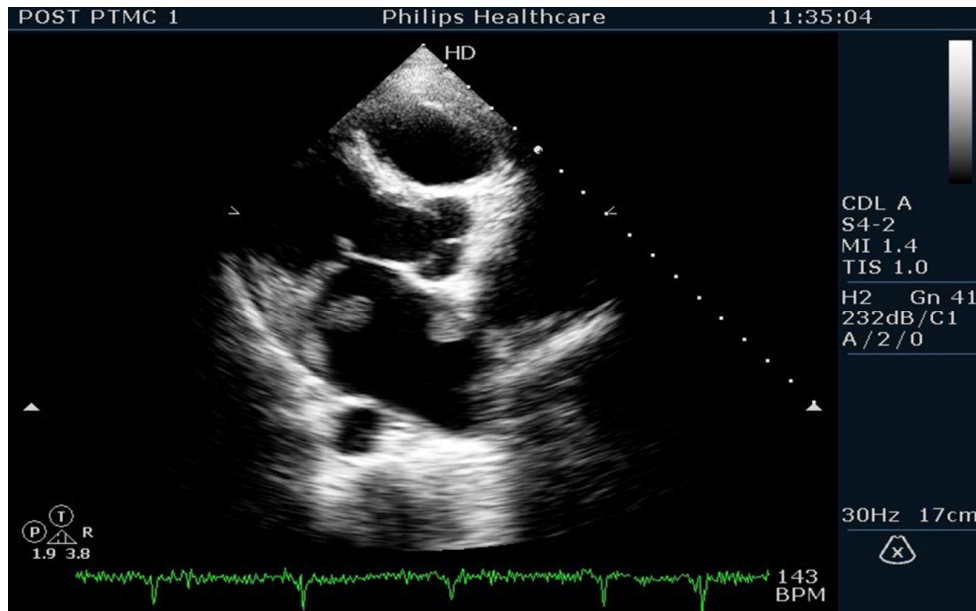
Parasternal long axis view showing two distinct clots in left atrium
